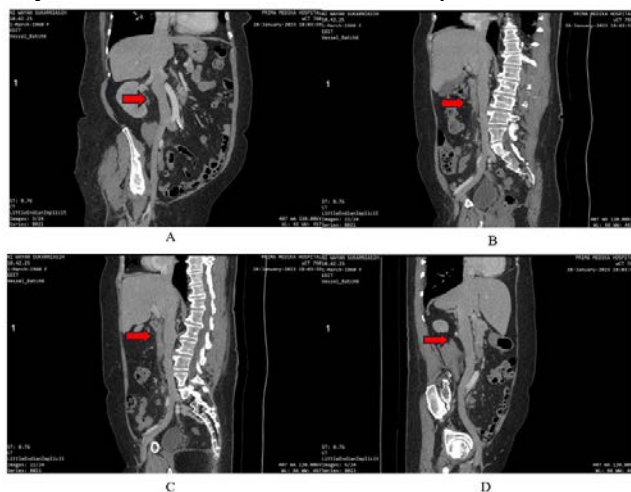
CT scan thorax showing filling defect along IVC consistent with thrombosis
